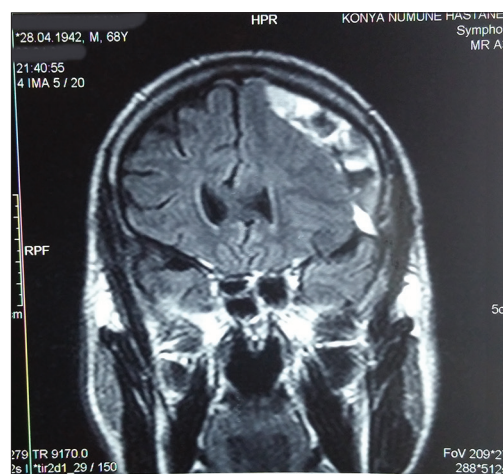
Preoperative T1-weighted magnetic resonance imaging showing multiple intrahematoma loculations with hypointense web-net-like structure within the left hemispheric organized chronic subdural hematoma
